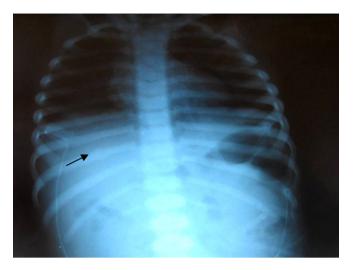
Anteroposterior chest radiograph shows a 9th rib fracture. There is callus formation surrounding the fracture, which indicates that this is an old injury.
